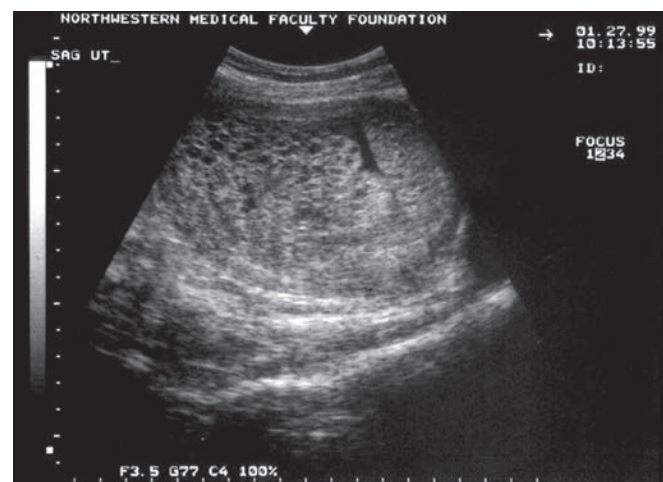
Ultrasound of complete hydatidiform mole. The characteristic vesicular “snowstorm” pattern of multiple echoes, appearing as holes within the placenta. No fetus is present.
